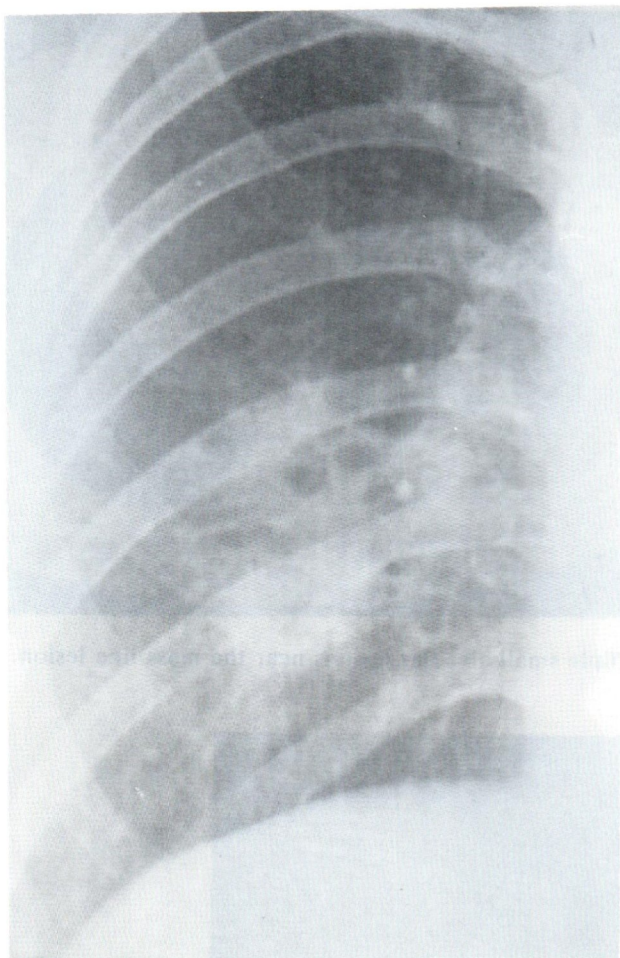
Plain film of the chest at right lower lobe, 2 months away from Samitivej Hospital, showed widened area of the lesion, probably due to inadequate treatment.
